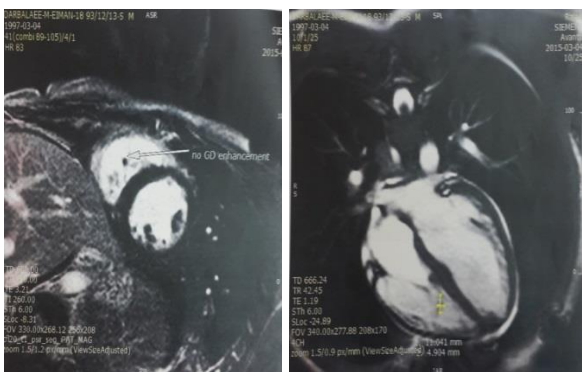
Cardiac magnetic resonance imaging (MRI) shows a clot in the right ventricle (RV)
